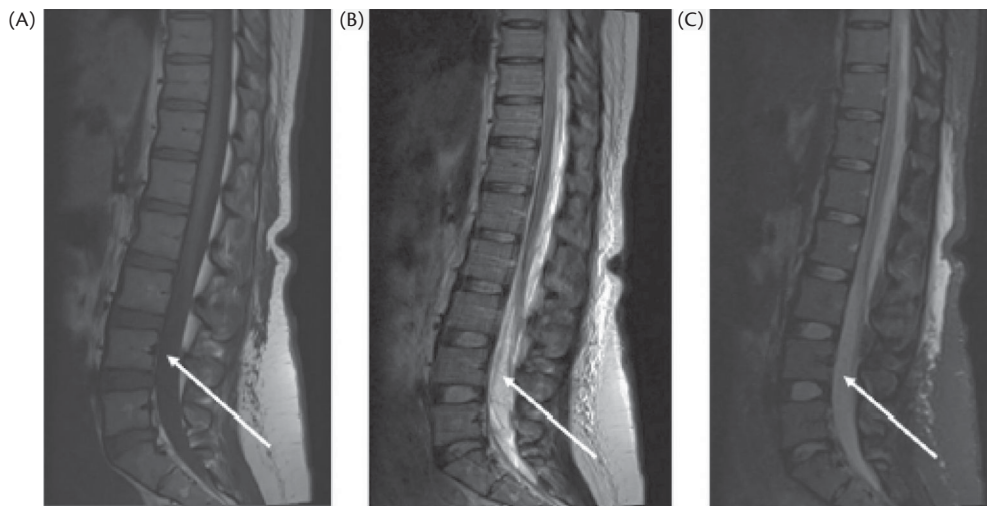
MRI images 48 hours after CSE anaesthesia, approximately 44 hours after the onset of sensorimotor symptoms. (A) Lumbar spine sagittal T1-weighted image showing haematoma up to L2–3 (arrow) which is difficult to identify due to isointensity with spinal cord and CSF. (B) Lumbar spine sagittal T2-weighted inversion recovery image with fat saturation showing heterogenous collection between L3 and L5 (arrow) in the caudal sac with compression of the cauda equina and nerve root displacement. (C) Sagittal turbo inversion-recovery image with fat saturation showing a hypointense area of the dural sac from L3 to S1 (arrow), consistent with CSF contamination with blood.
